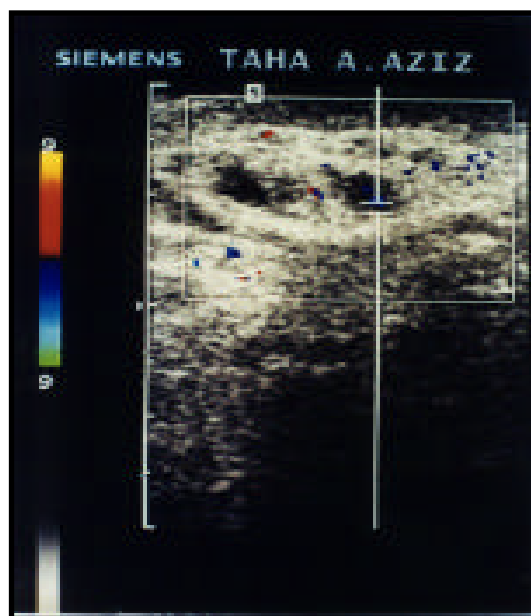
Color duplex ultrasonography showing the previously dilated pampiniform plexus with no blood flow inside (Valsalva manoeuvre).
